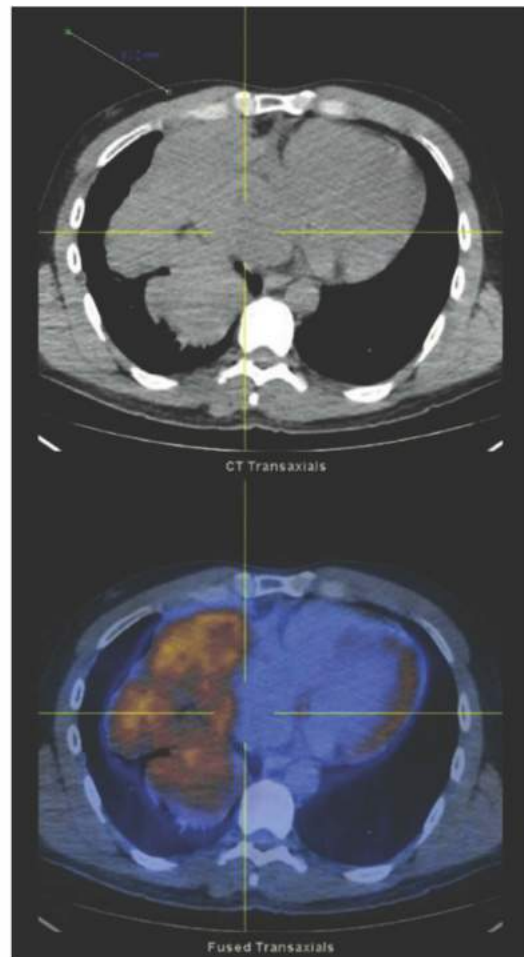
• Positron emission tomography (PET) scan. Standard uptake value (SUV) of 6.5 in biopsy-proven thymoma measuring 14 cm × 8.3 cm in 38-year-old male.
